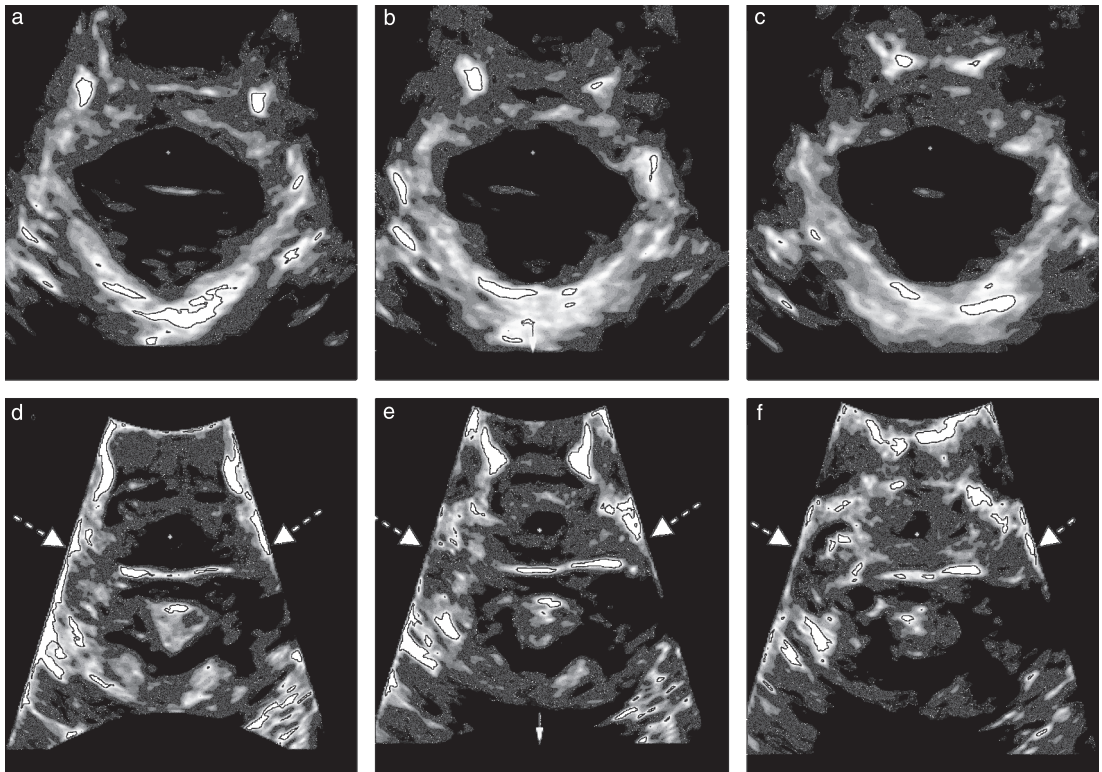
Tomographic ultrasound images of intact levator ani muscle (LAM) (a–c) and bilateral LAM macrotrauma (d–f) (arrows) in plane of minimal hiatal dimensions (a,d) and slices 2.5 mm (b,e) and 5.0 mm (c,f) cranial to this.
